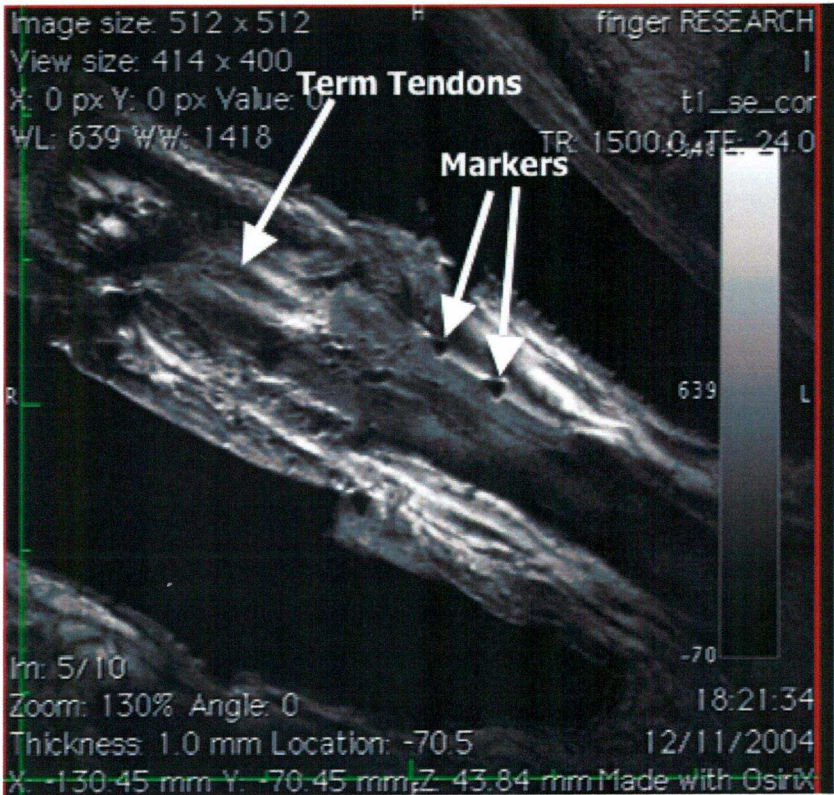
Coronal MRI markers in-situ
